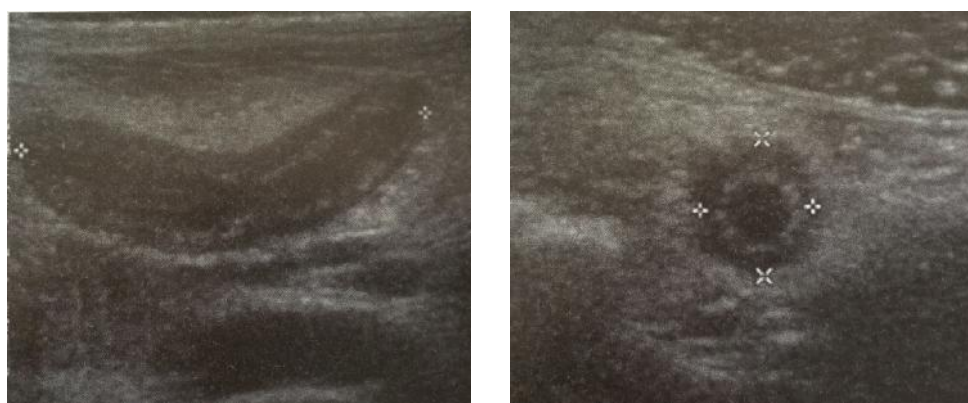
Longitudinal and transverse sonogram showing an enlarged tubular appendix (between calipers) that was non-compressible³⁵.
